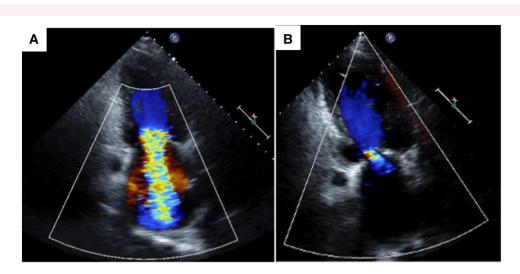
Mitral valve echocardiography (A) preoperative image. (B) Postoperative image.
